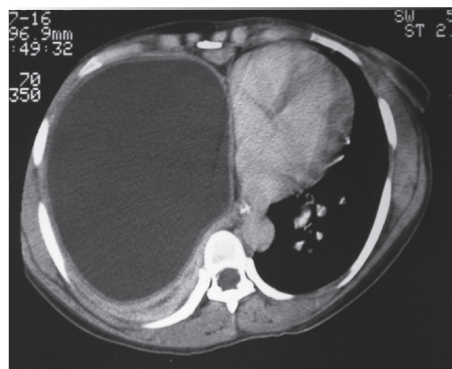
CT chest imaging demonstrating the presenting features of a pulmonary hydatid cyst. A large cystic lesion with a thin border occupies the lower right chest cavity, with associated mass effect on the heart which is displaced to the left.
